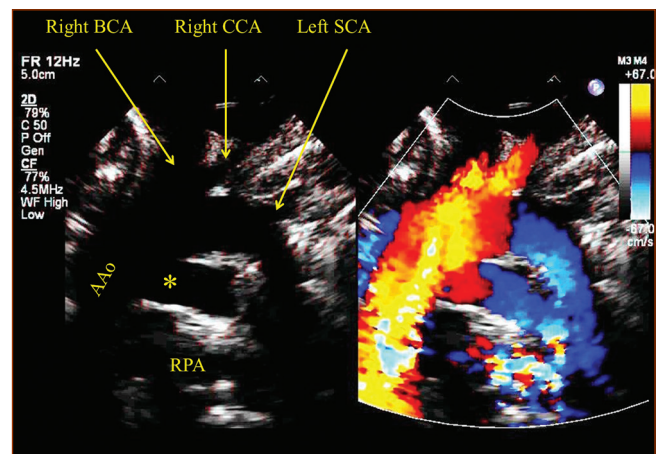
Transthoracic echocardiogram in suprasternal long axis view shows left-sided aortic arch with normal branching pattern of neck vessels. A vascular channel (*) originates unequivocally proximal to the origin of the right brachiocephalic artery and terminates at the pulmonary artery confluence. The pulmonary end of this vascular channel is constricted with turbulence seen on color Doppler interrogation (right panel). AAo = Ascending aorta, BCA = Brachiocephalic artery, CCA = Common carotid artery, RPA = Right pulmonary artery, SCA = Subclavian artery
